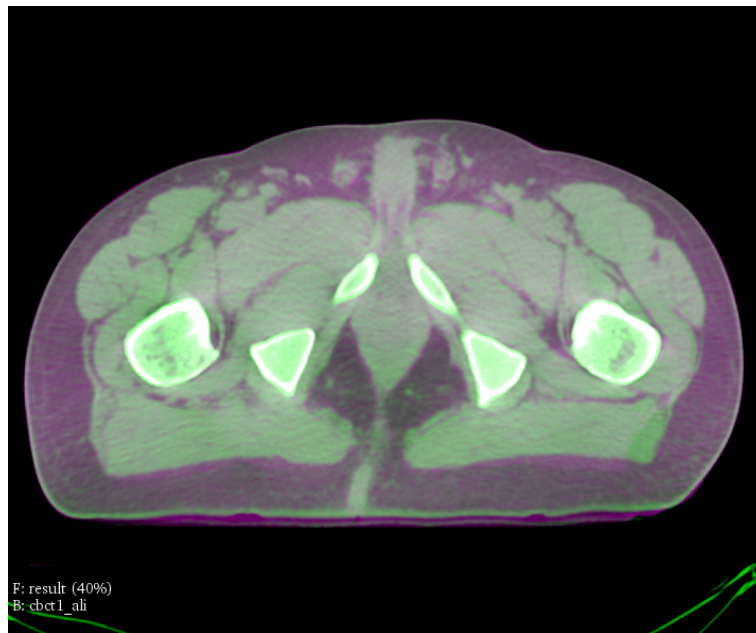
Comparison of virtual CT produced by author's code and CBCT after DIR.
